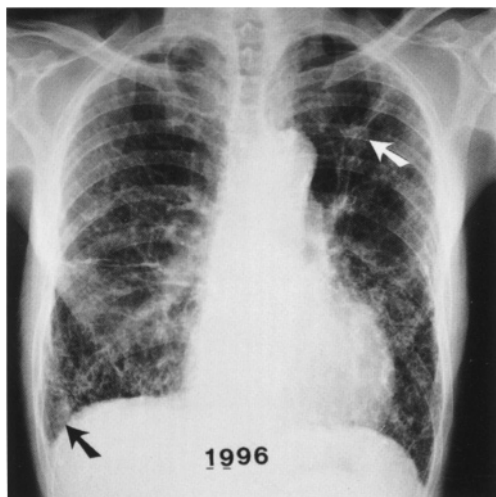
A PA chest radiograph reveals diffuse irregular opacities of s-size throughout both lungs. There are two small irregular tumours in the right costophrenic angle (*black arrow*) and in the left upper lobe (*white arrow*), respectively. The appearance suggests lung cancers. The ILO classification is 3/3, s/s, ca, pi, ho, pc
